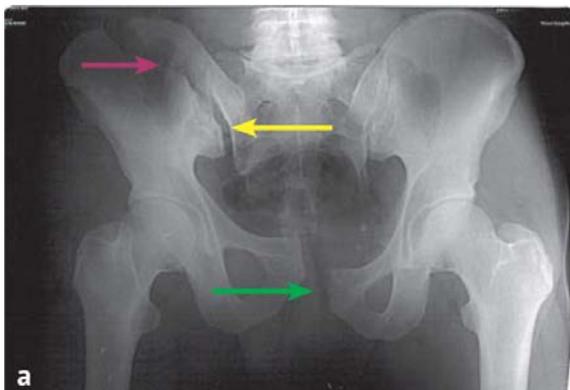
Radiography image of the patient with unstable pelvic fractures: *a* – before surgery, *b* – after surgery
